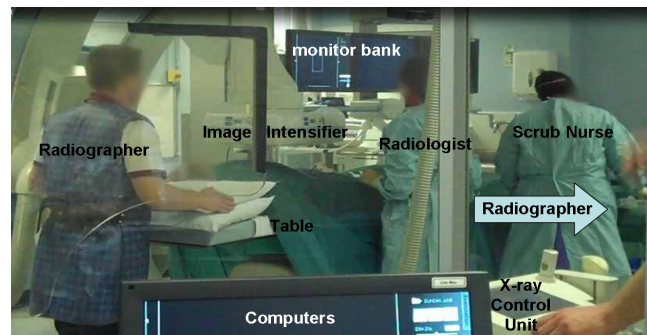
View towards x-ray table from computer area.
